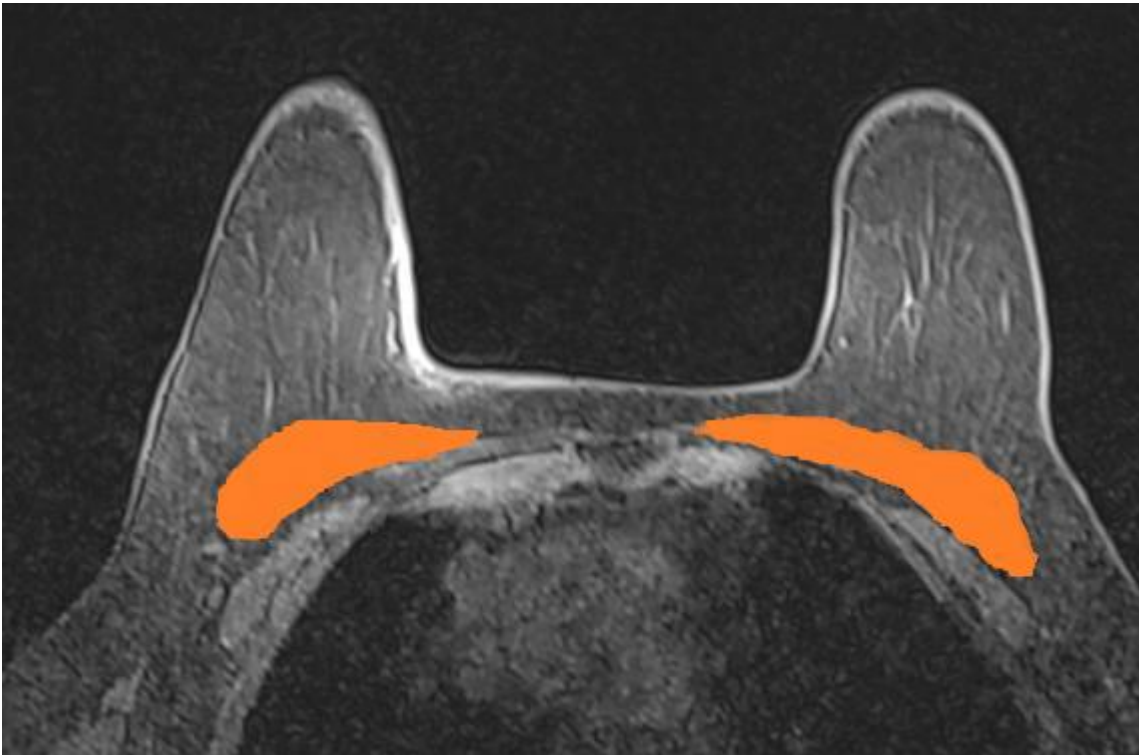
a) 35-year-old woman with invasive ductal breast carcinoma in the lower outer quadrant of the right breast, who performed breast MRI before starting NAC. b)
